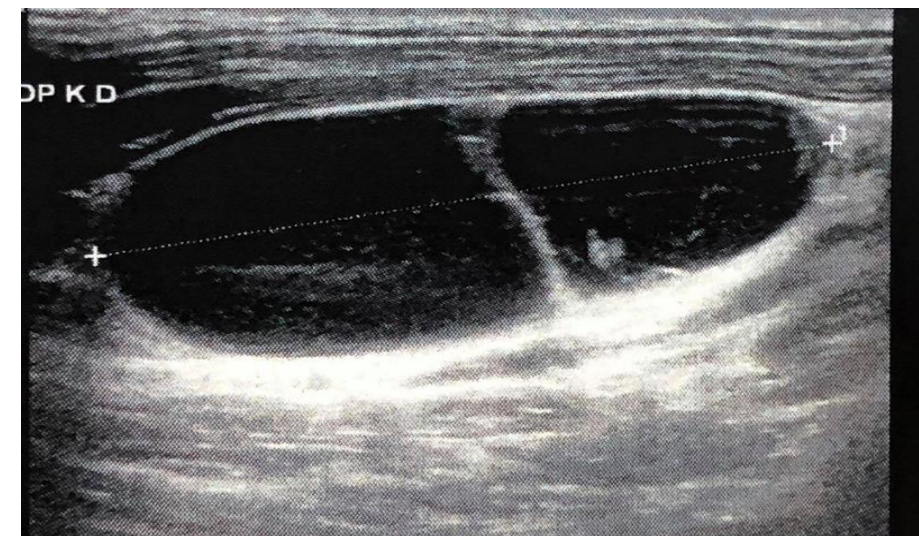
Cervical ultrasonography showing cervical cystic lymph node
